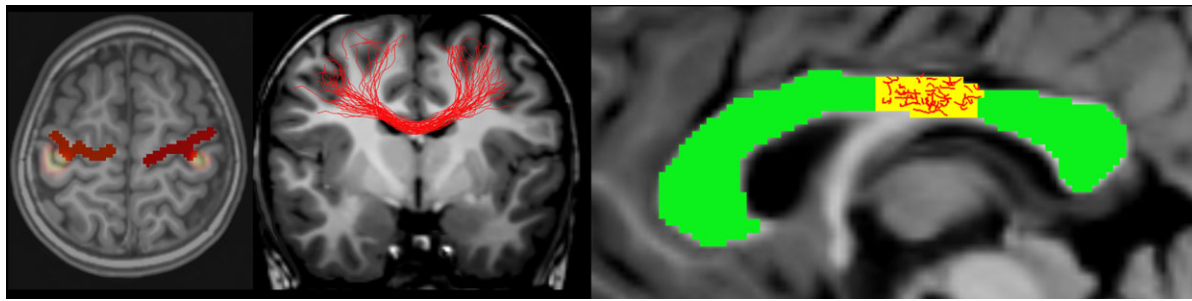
Constrained-spherical, deconvolution-based probabilistic tractography was used to identify the transcallosal motor fibres (in red) connecting the primary motor cortex (middle), which was delineated anatomically as described previously.²⁶ In addition, functional magnetic resonance imaging activation of hand movements was used as additional guidance for identification of the precentral gyri. The midsagittal area of the corpus callosum (green) and its motor part (yellow, as defined by the transcallosal fibres) were traced manually. [Colour figure can be viewed at wileyonlinelibrary.com].
